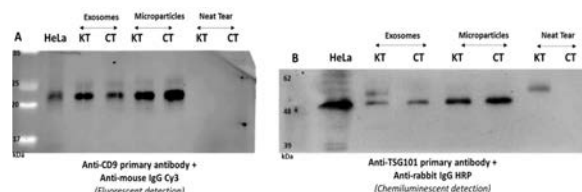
Immunoblot analysis of tear EVs for CD9 and TSG101. Microparticle and exosome proteins were resolved and transferred to a NC membrane. The blot was probed for CD9 (A) and TSG101 (B). HeLa cell lysate was used as a positive control for both markers and neat tear was also included for comparison. CT, control tear; KT, keratitis tear
